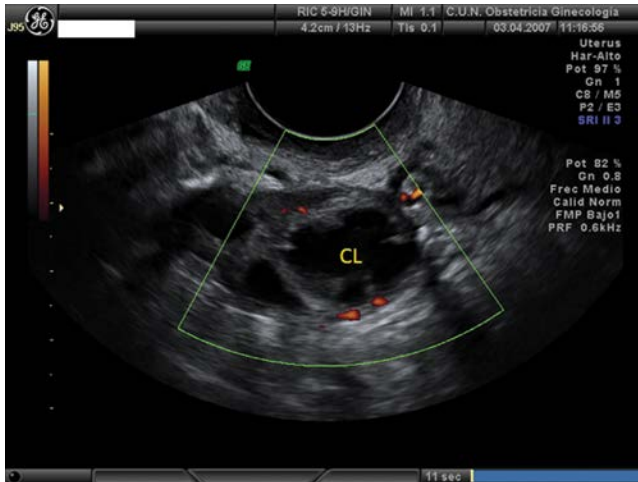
Transvaginal ultrasound showing a corpus luteum (CL) in the left ovary, after ovulation.
